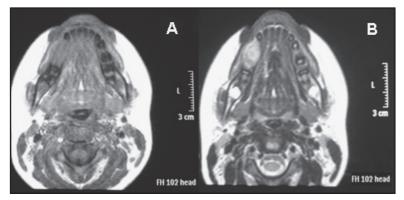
Magnetic resonance images, in T-1 (a) and T with contrast (b), showing hyposignal of the lesion and delimitation of the lesion on the external surface.
